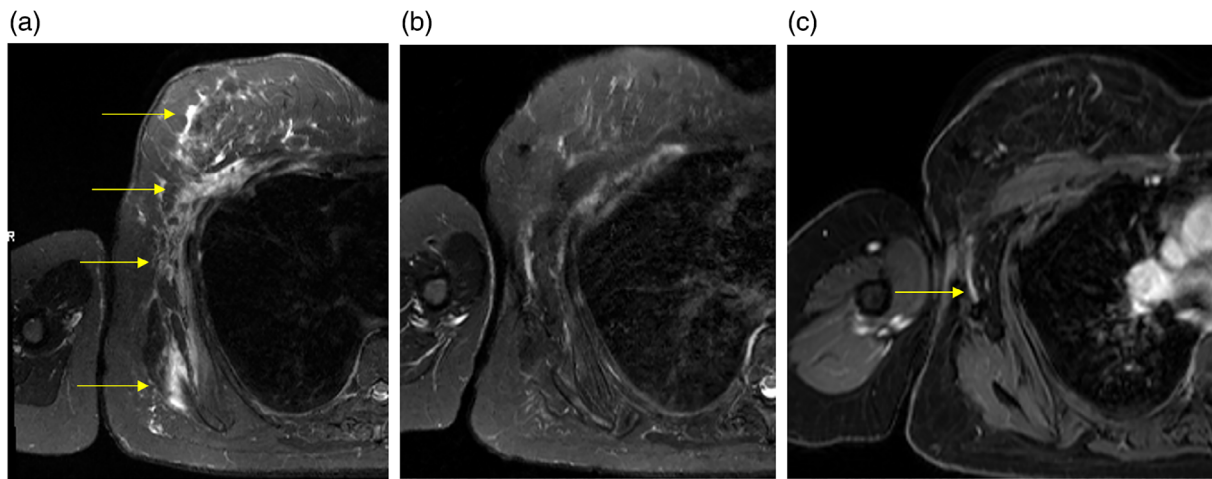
Reduction of right breast and chest wall edema following VLNT. (a) Preoperative axial T2-weighted short-tau inversion recovery (STIR) magnetic resonance (MR) image demonstrated moderate edema throughout the right breast and chest wall, denoted by hyperintense areas (arrows). (b) Two-year postoperative axial STIR image showed only trace edema. (c) Post-contrast axial T1-weighted gradient recall echo (GRE) MR image showed patent vascular pedicle (arrow).
